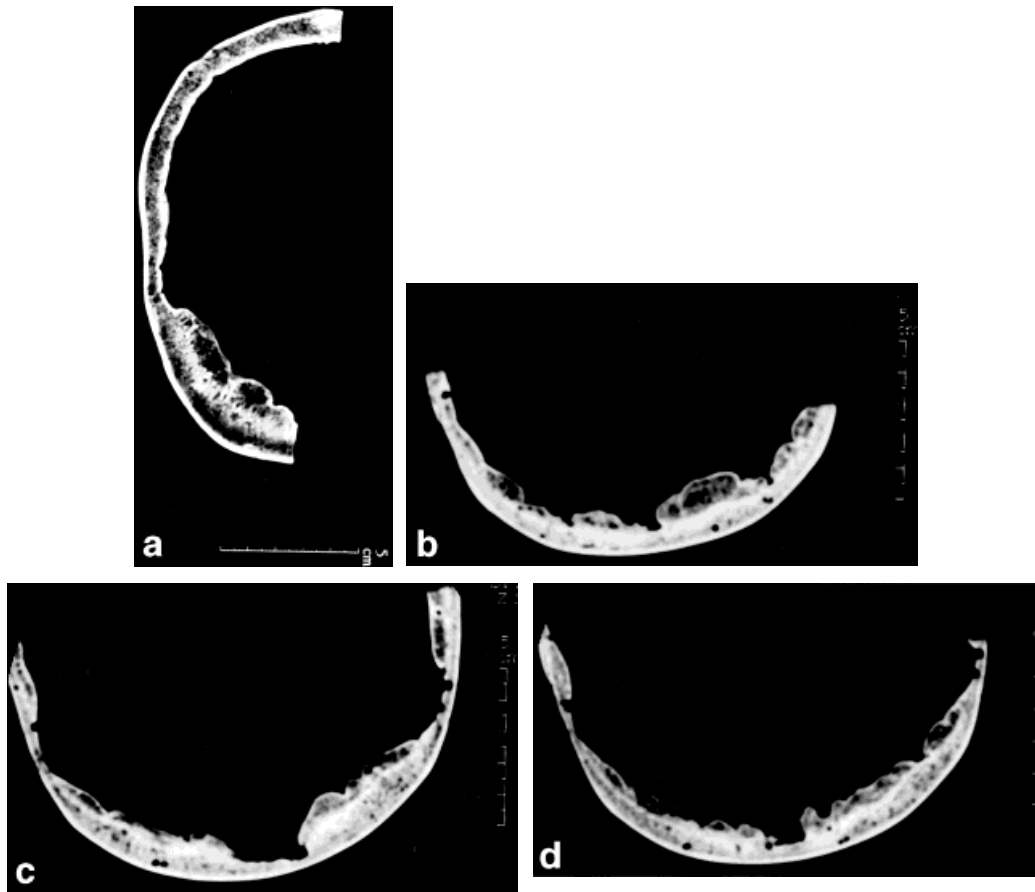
CT scans of advanced HFI (stage D) in three different individuals (a–d). Note that while ectocranial plate and diploic space retain their normal appearance in the region of the nodule, the normal endocranial plate is not seen. In its place, three different areas are identified: a hyperdense layer, a ballooned, vascularized area, and a thin cortical shell encapsulating it.
